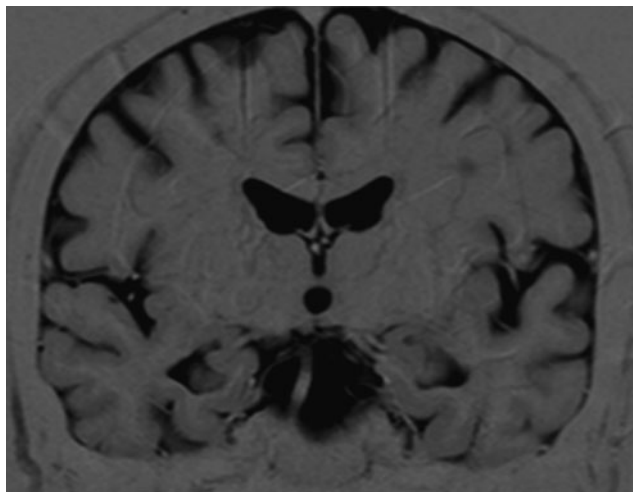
Magnetic resonance imaging true inversion recovery image demonstrating atrophy of the fornices and hippocampi.
